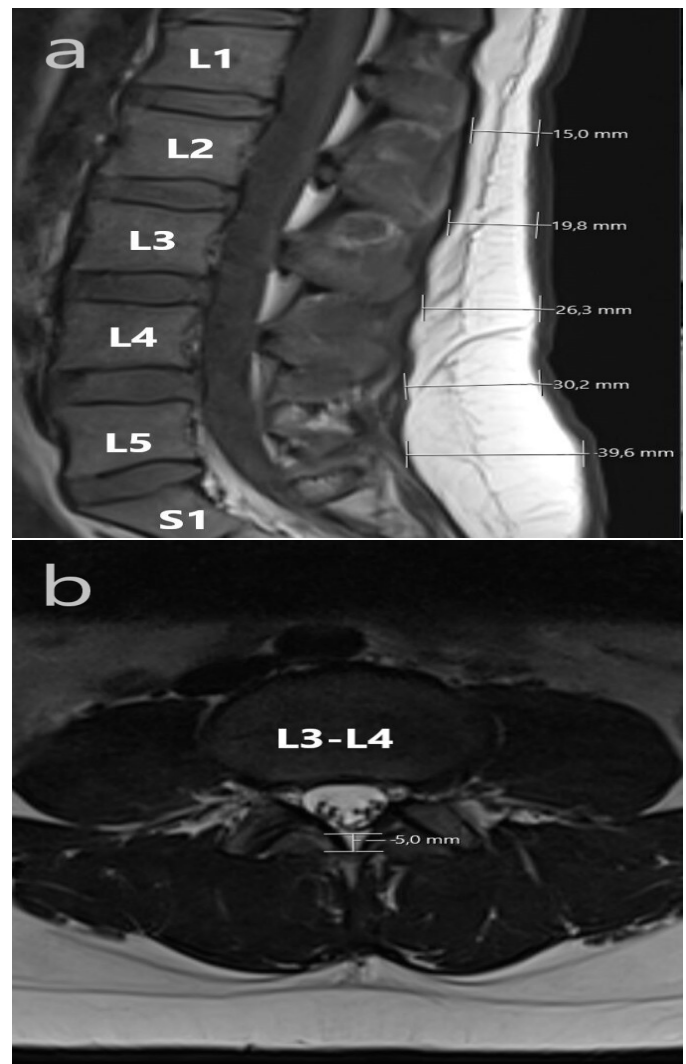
Measurement of EFTT and SFTT with lumbar MRI. SFTT measurement from sagittal T1 images (a), EFTT measurement from axial T2 images (b).
